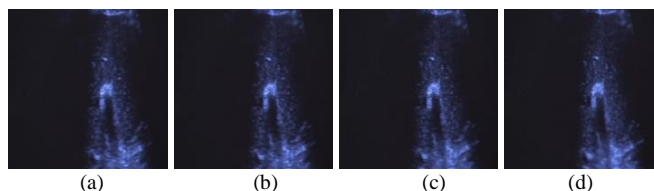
From a ~ d, the Frames Number 7, 8, 9 and 10 of the Ultrasound Sequence.
